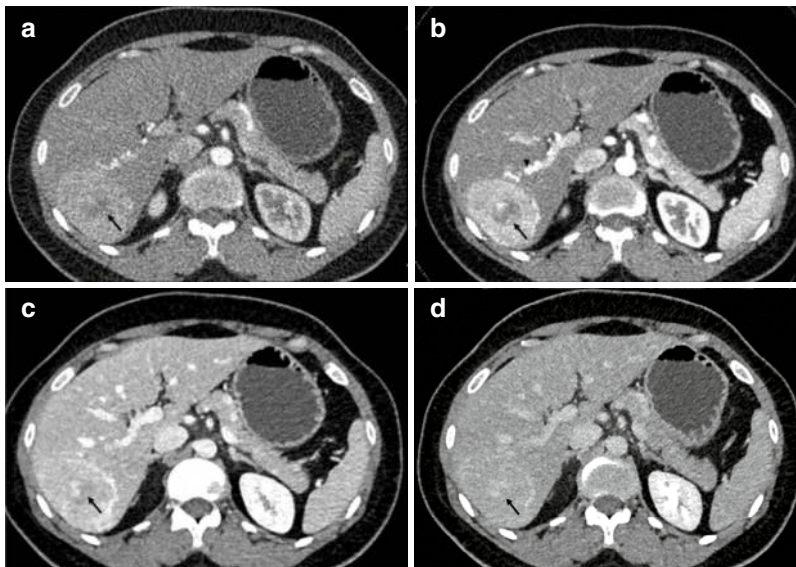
Focal nodular hyperplasia (FNH) on CT. Axial sections of dynamic-contrast CT depicting a circumscribed homogenous arterial-enhancing lesion in segment VII (a and b), showing washout in venous (c) and delayed (d) phase
